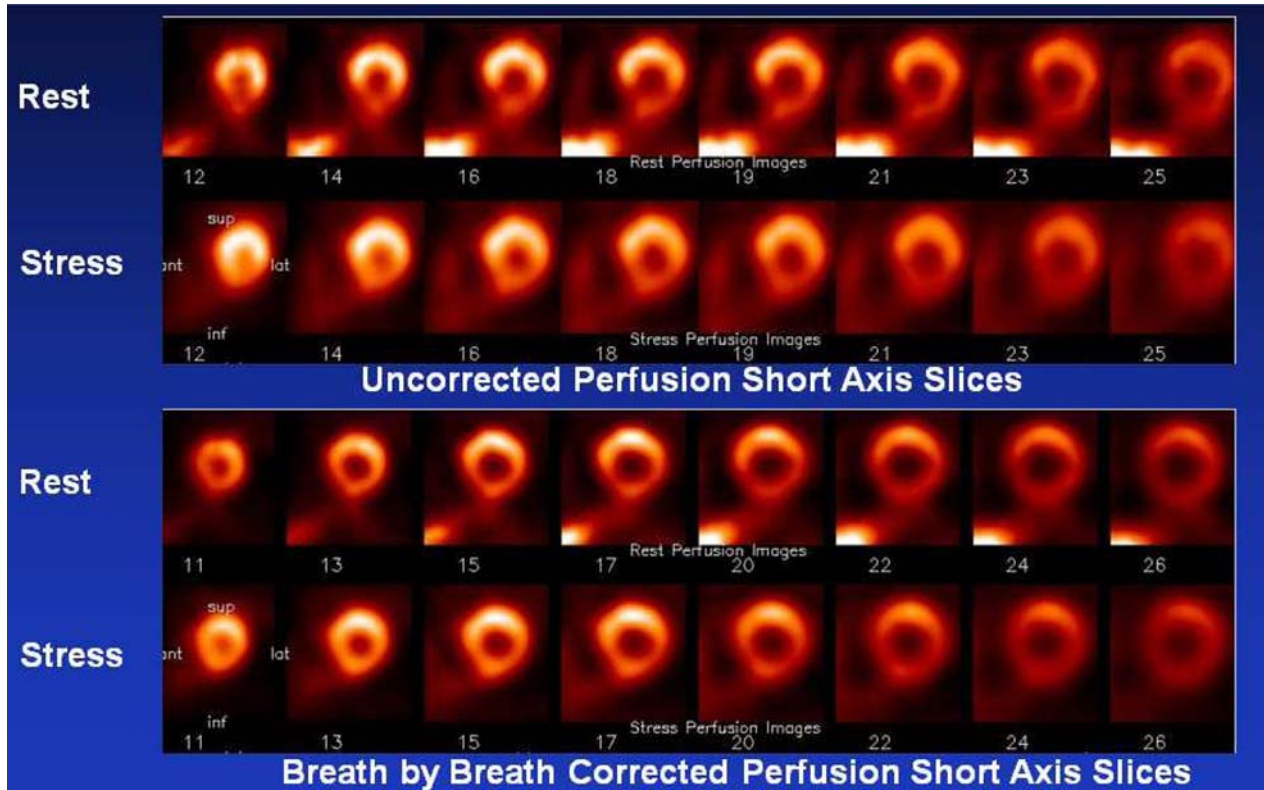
Short-axis reconstructed MP-SPECT™ images before (*above*) and after (*below*) correction for respiratory motion. The correction algorithm applied here breaks the list-mode acquisition into segments corresponding to individual R-to-R wave intervals and the image segment for each beat is shifted so that the centers-of-mass superimpose. Images courtesy of Dennis Kirch (Eagle Heart Imaging, Westminster, CO).
